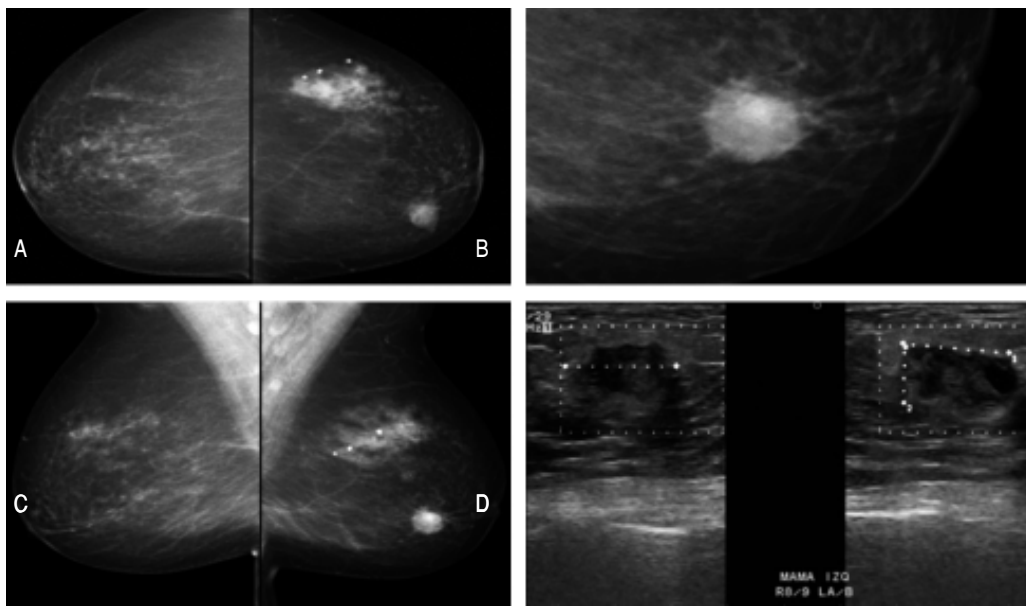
Characteristics of mammography and breast ultrasonography in idiopathic granulomatous mastitis (IGM). A 53-year-old female with IGM. Mammography shows left breast with focal asymmetry, a calcified nodule, and a spiculated nodule localized in the lower inner quadrant. Breast ultrasonography demonstrates an irregular nodule.
